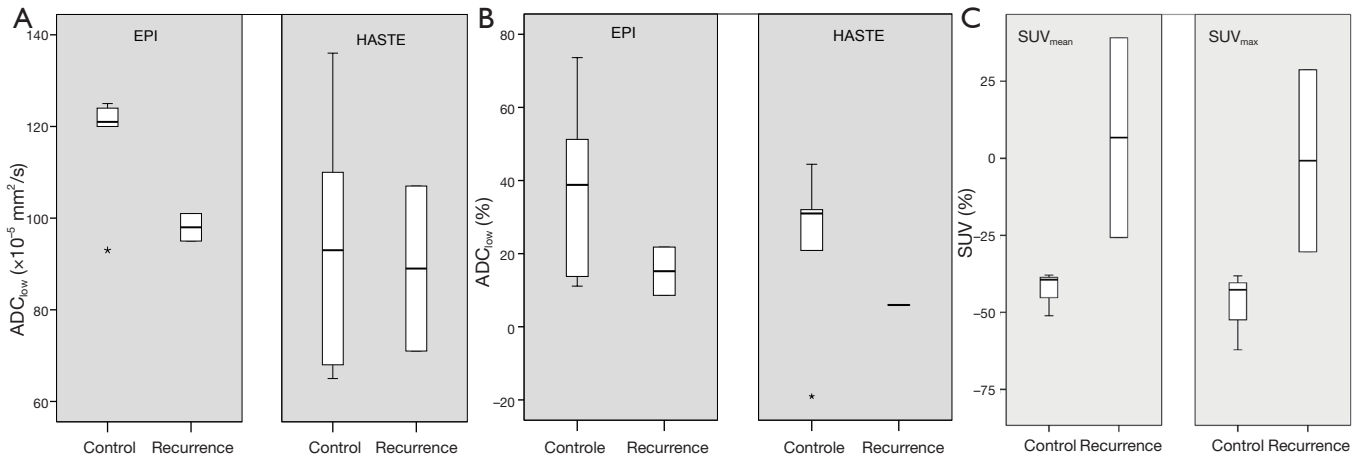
Comparison of lymph node (A) ADC_{low} at DW-MRI₂, (B) $\Delta ADC_{low-2weeks}$ (in %) and (C) ΔSUV_{2weeks} (in %), in six patients with regional control and two patients with recurrent disease. Box-whisker plots are presented with median (–), interquartile range (box), and range (–).
